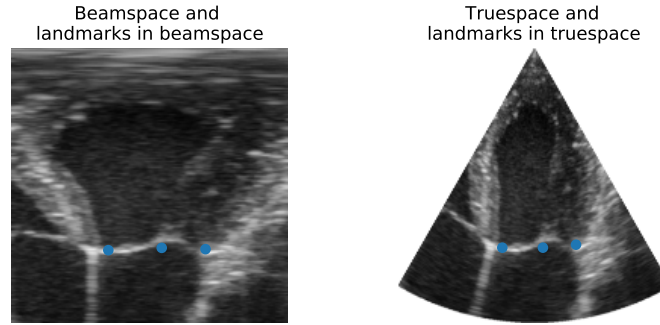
Cardiac ultrasound in the beamspace (r, θ) and the truespace (x, z) representation.
